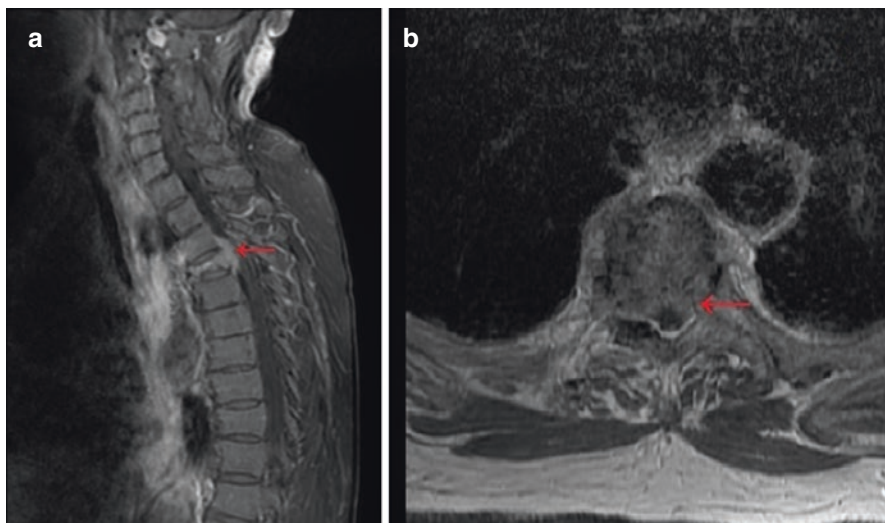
Thoracic spine T1-weighted MRI with contrast showing T4 pathological fracture with significant height loss, and an enhancing lesion with extension into epidural and bilateral foraminal spaces. (a) Midline sagittal view. (b) Axial view at T4 vertebral body level
